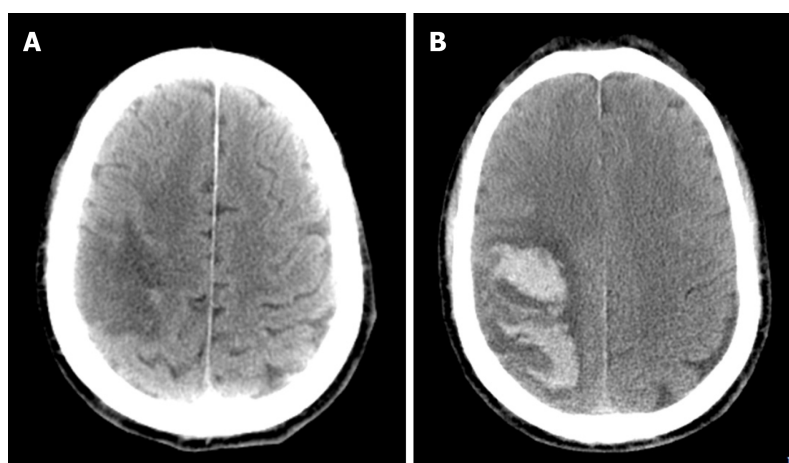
A 68-year-old man with parenchymal hematomas after acute ischemic stroke caused by polycythemia vera. A: Computed tomography (CT) revealed right parietal and temporal lobe infarction; B: CT re-examination after 3 d revealed a hematoma within the infarct lesion of the right cerebral hemisphere.
